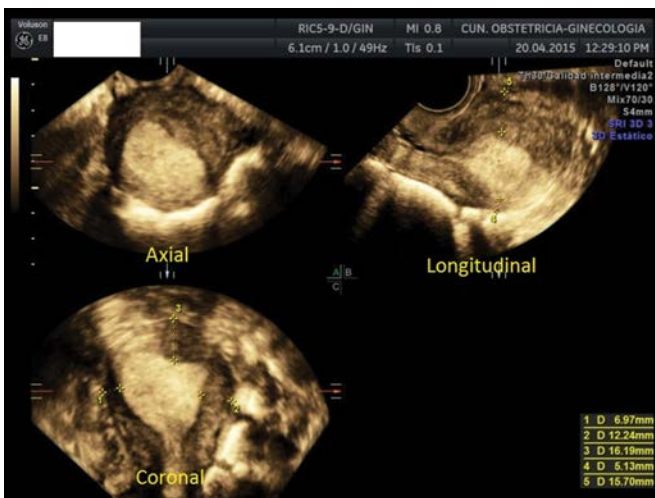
Myometrial infiltration estimated using virtual navigation with 3D ultrasound. Five measurements of myometrial wall thickness are performed in the anterior and posterior walls (longitudinal plane) and lateral and fundal walls (coronal plane). The shortest distance to serosa is 5.13 mm (measurement 4). This finding suggests deep myometrial infiltration at this site.
